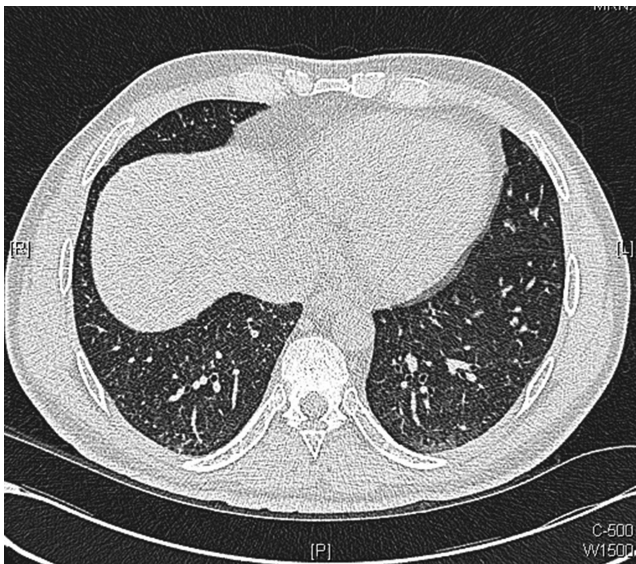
Axial images from repeat chest CT scans performed 10 days after initiation of antituberculosis medications: showing considerable improvement in appearance with disappearance of many of the tiny intrapulmonary nodules with resolution of thickened interlobular septa.
